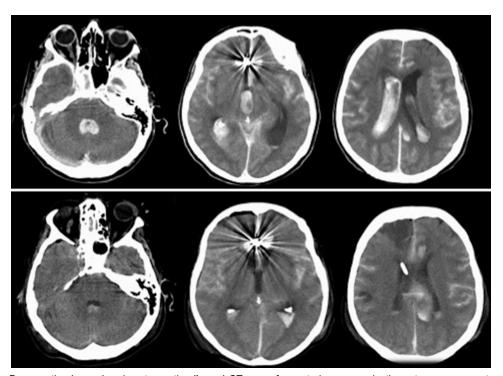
Preoperative (upper) and postoperative (lower) CT scan of an anterior communicating artery aneurysm, treated with emergency coiling and subsequent endoscopic surgery plus external drainage.
